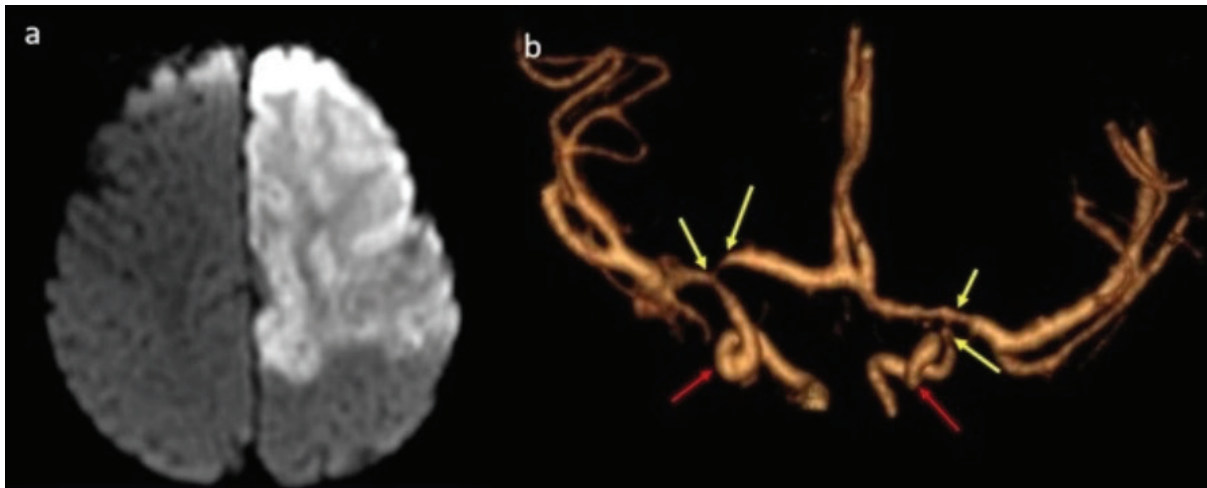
a) Diffusion-weighted MRI imaging, constraint restriction compatible with acute ischemia in the frontal and parietal on the left; b) CT angiography 3D VR imaging shows curvy distal ICA's with red arrows, slacks with yellow arrows
